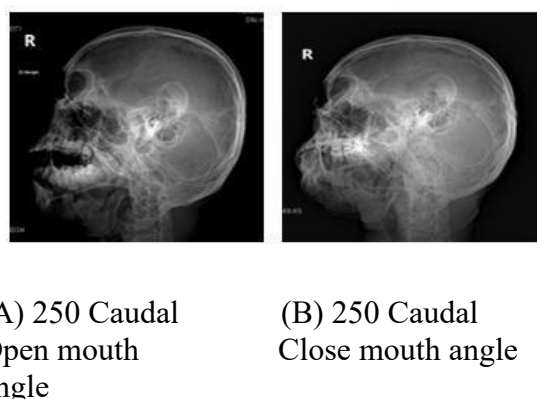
Temporomandibular Joint Radiograph Axialateral Projection 250 Caudal Angle
